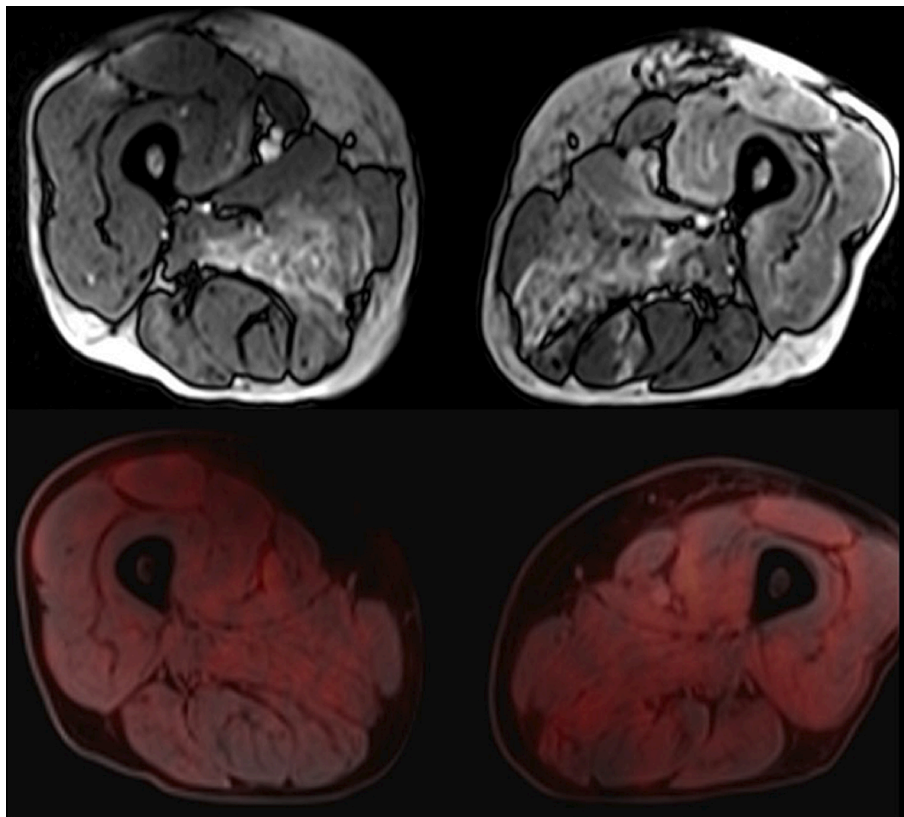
Muscle MRI shows T2 hyperintensities in the muscles of the anterior, posterior & adductor compartment of thigh bilaterally. 18FDG-PET shows increased tracer uptake in the muscles of the anterior, posterior & adductor compartment of thigh bilaterally.
